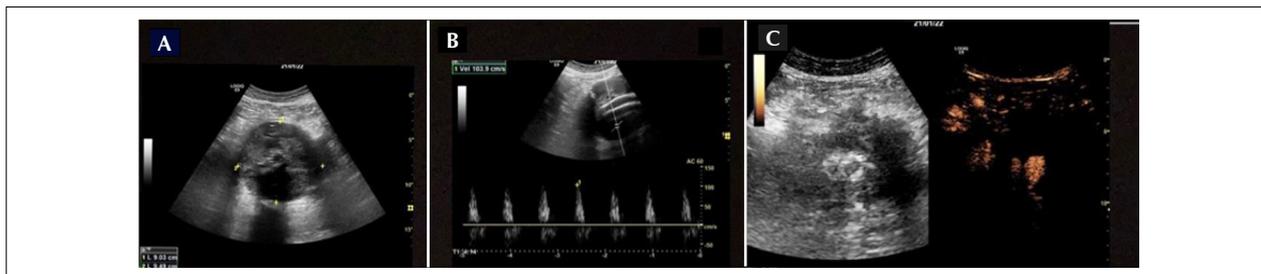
(A) B-mode ultrasound image used to take anteroposterior and transverse diameter measurements. (B) Spectral Doppler image showing high-velocity flow inside the aneurysmal sac. (C) Contrast-enhanced ultrasound (SonoVue, Bracco) image showing leakage through the right branch of the endoprosthesis.
